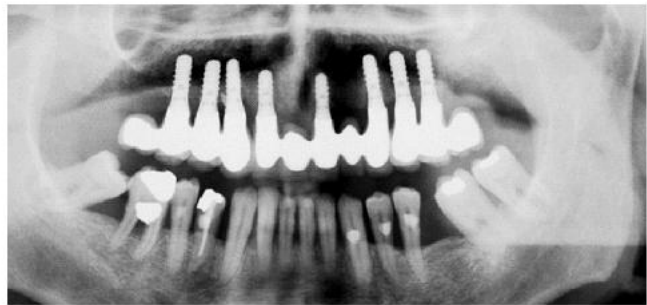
Final radiographic view. Ideal bone-to-implant contact has been achieved.
